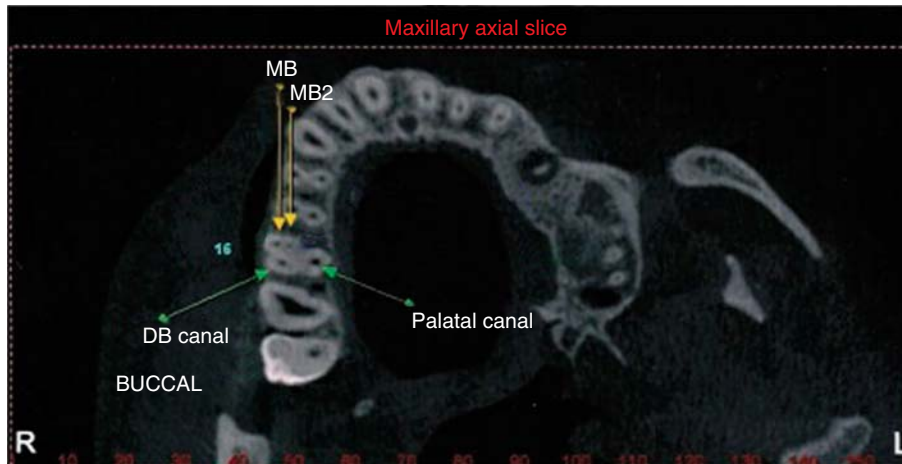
CBCT analysis showing two canals in the MB root: MB and MB2.
